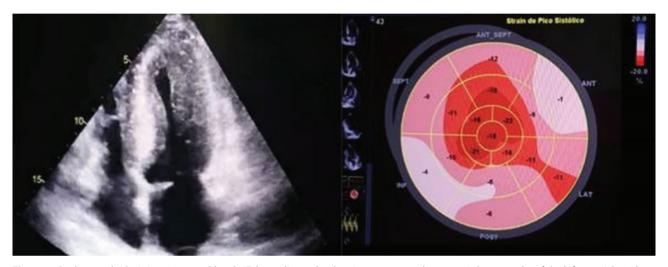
Cardiac amyloidosis in a 36-year-old male: Echocardiography showing accentuated concentric hypertrophy of the left ventricle with an appearance suggestive of a deposit disease and signs of increased filling pressure, moderate increase of the right atrium and hypertrophy of the right ventricle.
